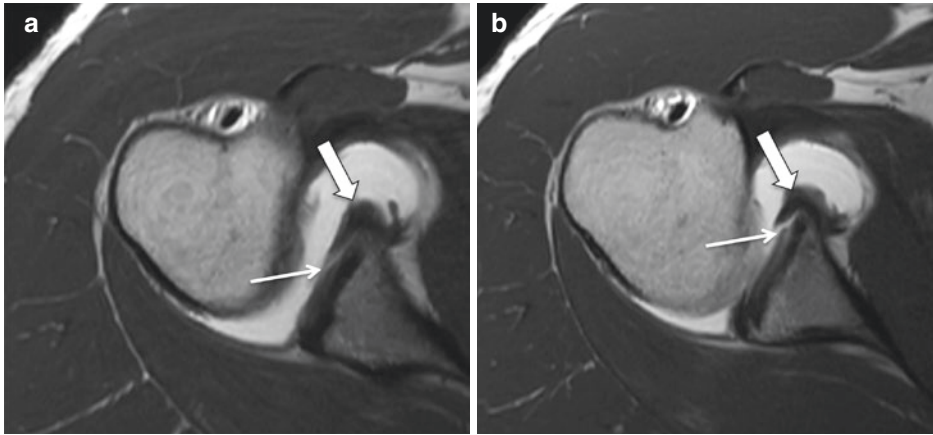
Glenolabral articular disruption (GLAD). Axial (a and b) nonfat-saturated T1-weighted MR arthrographic MR images showing a tear of the anteroinferior labrum
